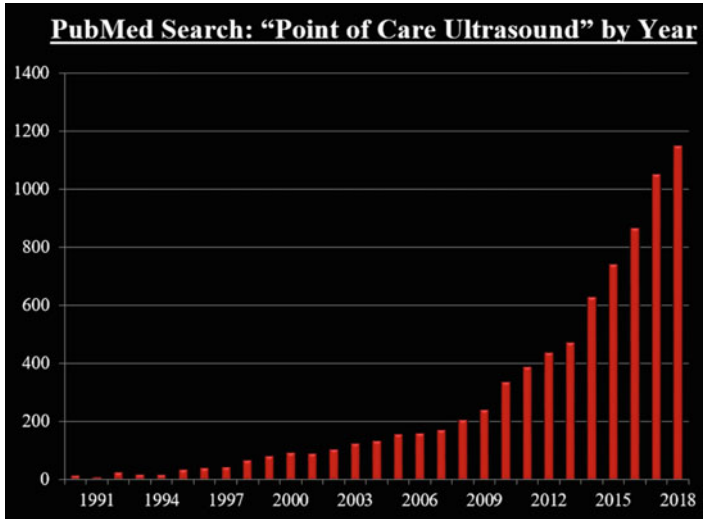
Pubmed search by year for Point-of-care Ultrasound
